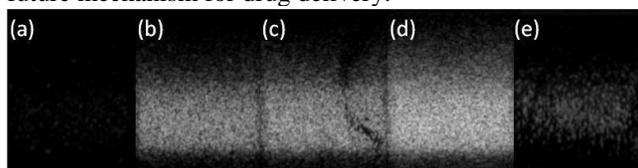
Ultrasound images of TEOS-MPTMS-TEOS capsules. The gain was kept at 10Db with increasing M.I, MI = a) 0.07, b) 0.44, c) 0.52, d) 0.8 and e) 1.2.
